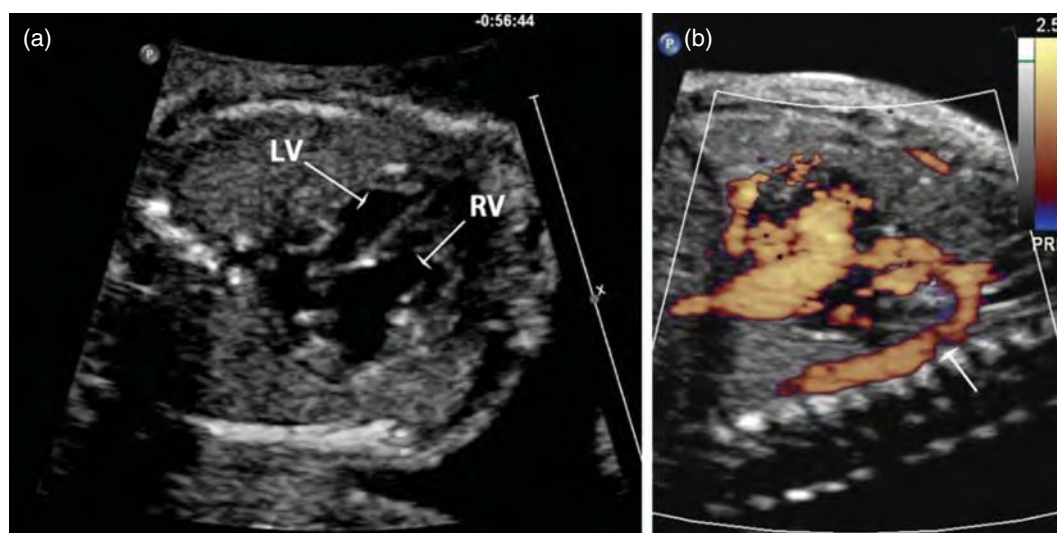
(a) Fetal echocardiogram showing ventricular disproportion with right ventricular dilatation; (b) power Doppler showing the area of coarctation marked by an arrow. LV, left ventricle; RV, right ventricle.
